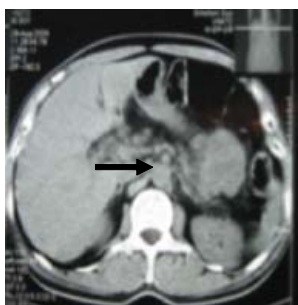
CT scan of abdomen showing distal pancreatic mass
